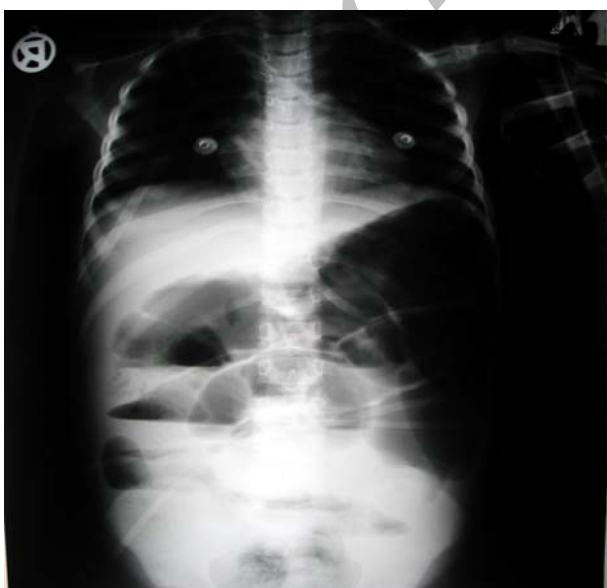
Plain abdominal X-ray of the patient.
